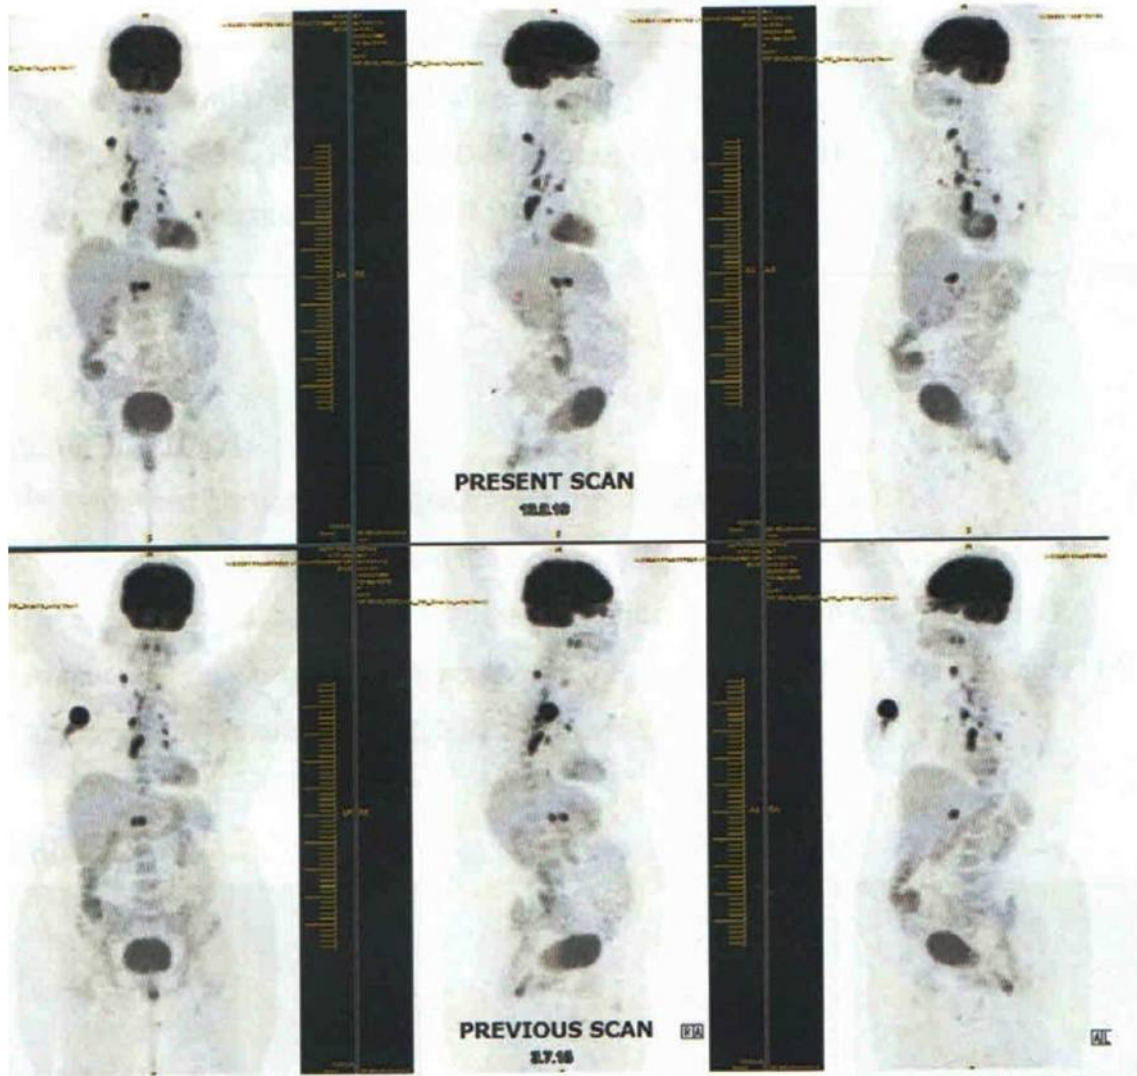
18F-FDG PET/CT images showing comparative results of recent and earlier scan
